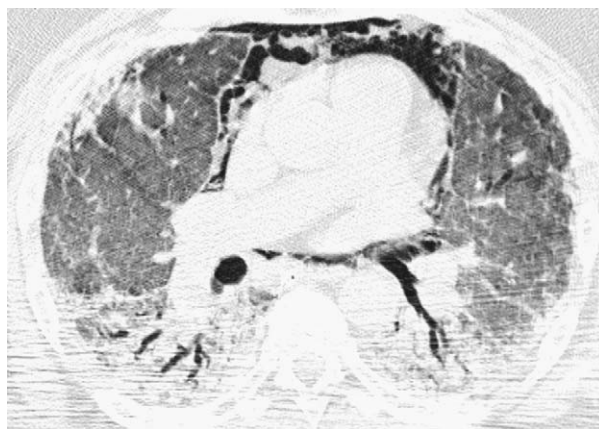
Acute interstitial pneumonia in a 65-year-old man. HRCT image at the level of the bronchus intermedius shows diffuse bilateral ground-glass opacities and areas of consolidation mainly in the dependent lung regions. Also noted is pneumomediastinum. Surgical biopsy showed diffuse alveolar damage.
